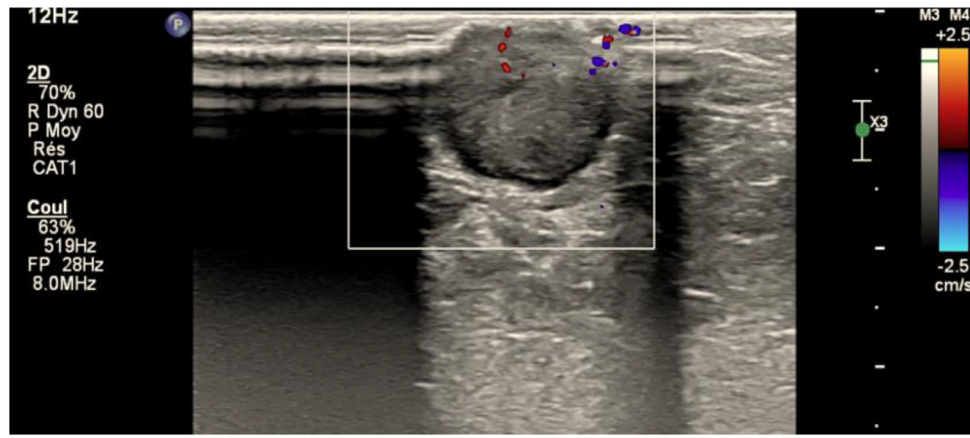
Ultrasound image of the axillary mass reveals a heterogeneous hypoechoic dermo-epidermal mass.
